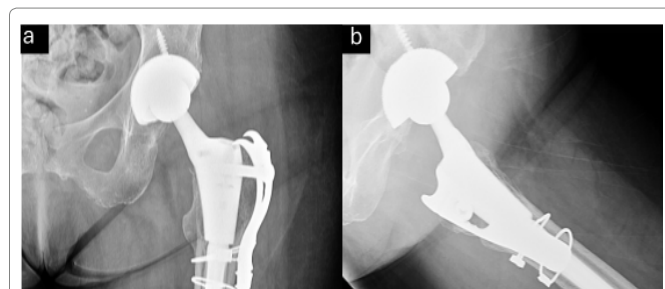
Case 4: Post-revision anteroposterior (a) and lateral (b) radiographs with no signs of impingement.
